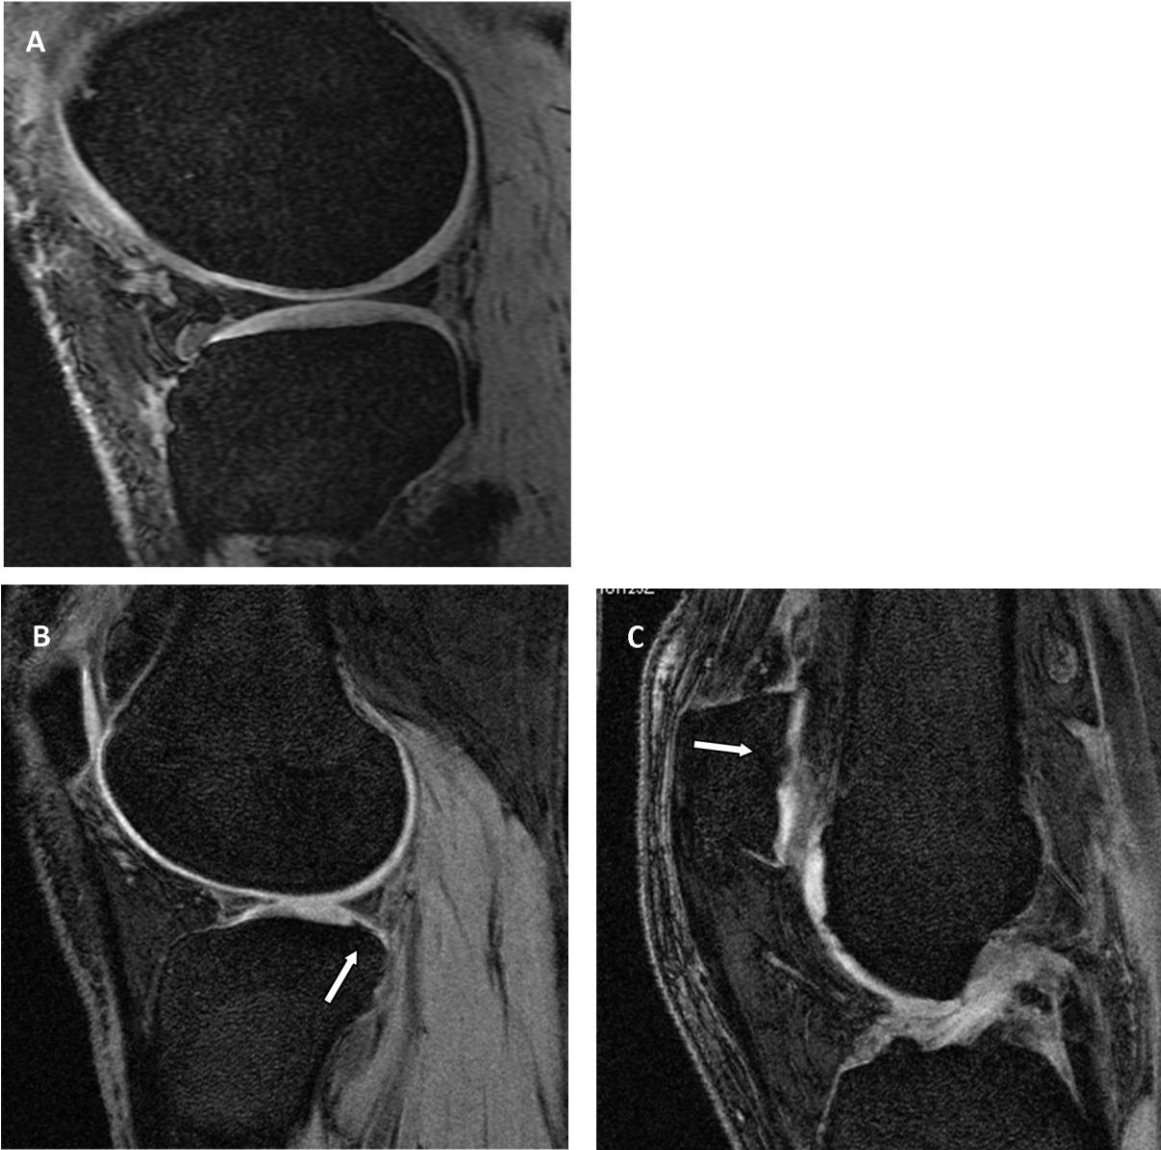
MRI images of A) a healthy knee, B) a knee with a tibial cartilage defect indicated by the arrow, and C) a knee with a patella cartilage defect indicated by the arrow.
